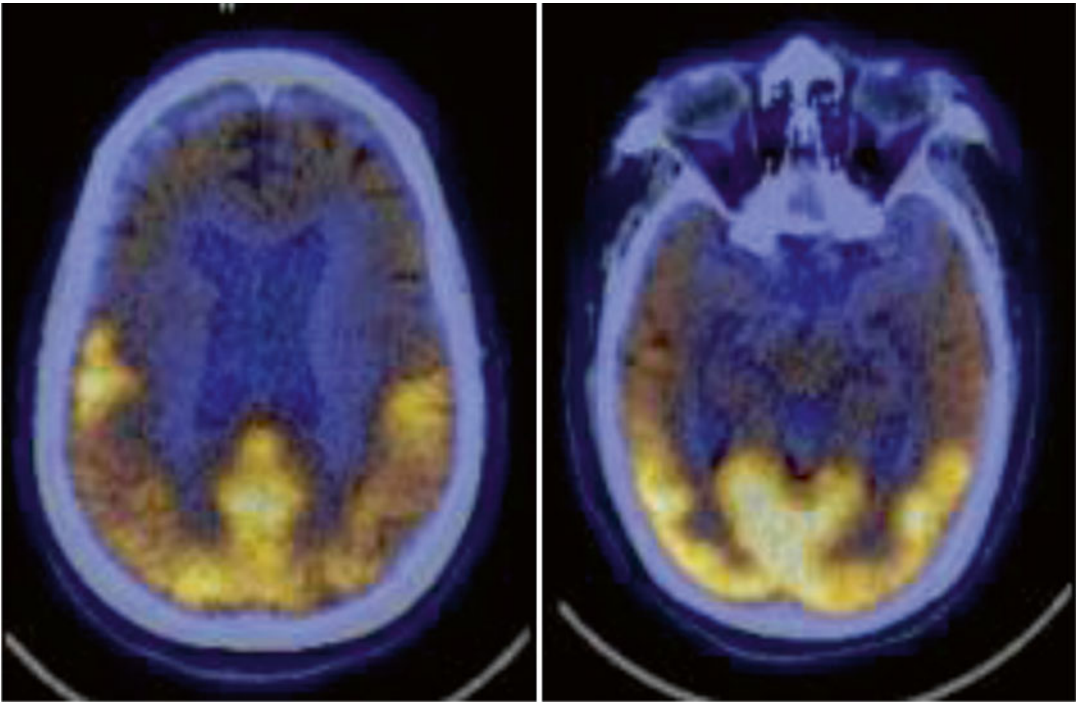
Transaxial fused ^{18}F -FDG PET-CT image of a case of frontotemporal dementia (behavioral variant), classical metabolic pattern with frontal (*left*) and temporal (*right*) hypometabolism
